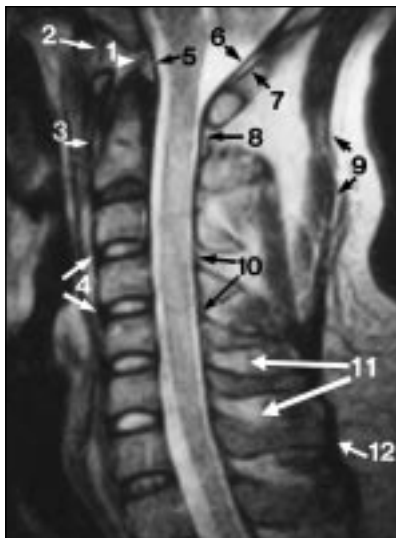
Normal anatomy in 43-year-old woman. Sagittal T2-weighted MR image (TR/TE, 4500/117) obtained on 0.3-T MR scanner shows normal apical ligament (1), anterior occipitoatlantal membrane (2), anterior atlantoaxial membrane (3), anterior longitudinal ligament (4), tectorial membrane (5), dural reflection (6), posterior occipitoatlantal membrane (7), posterior atlantoaxial membrane (8), nuchal ligament (9), flaval ligaments (10), area of interspinous ligaments (11), and supraspinous ligament (12).
